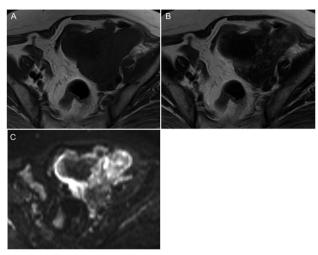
Axial images of MRI of the pelvis demonstrate a lobulated solid mass showing hypointensity on T1-weighted imaging (A). Hypointensity containing granular or small irregular-shaped foci of intermediate signal on T2-weighted imaging (B). Heterogeneous signal intensity on diffusion-weighted imaging, especially hyperintensity in the tumor's peripheral zone (C).
